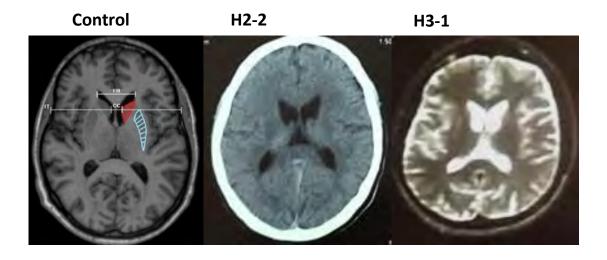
Brain MRI imaging of HD patients (H2-2 and H3-1) was compared with normal healthy control. Anatomical landmarks of the basal ganglia (putamen in blue and caudate in red) are shown on the normal T1 axial MRI, with measurement markers of atrophy (CC: inter-caudate distance; FH: frontal horn distance of lateral ventricles; IT: inner table of the skull). In contrast, severe caudate and frontal-predominant global atrophy are demonstrated in an MRI of HD patients. Normal brain MRI image adapted from Goh et al., (2018).
